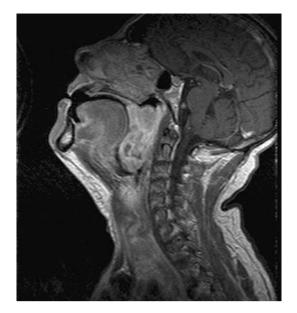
Coronal MRI image
